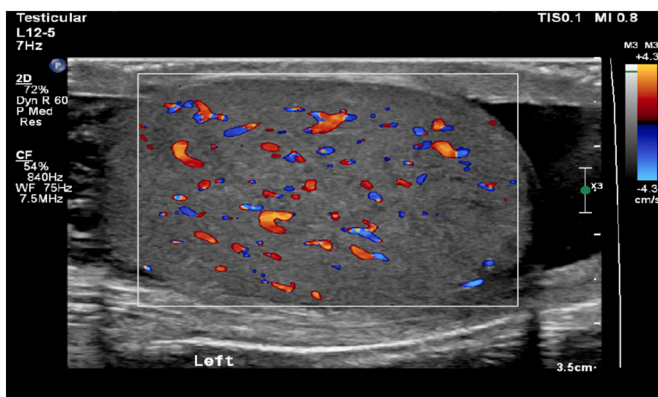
Left testis ultrasound post-manual detorsion.
